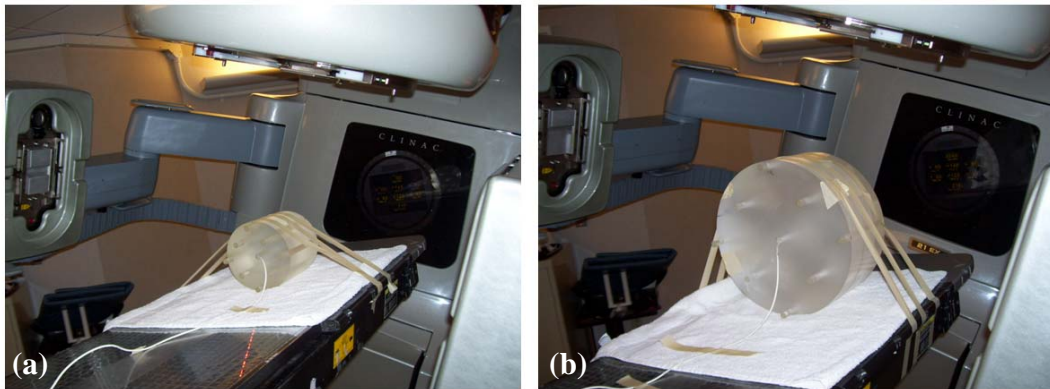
Experimental setups for new CBCT scan protocols. (a) standard-dose head, low-dose head, and high-quality head, (b) pelvis, pelvis spotlight, and low-dose thorax scans.
